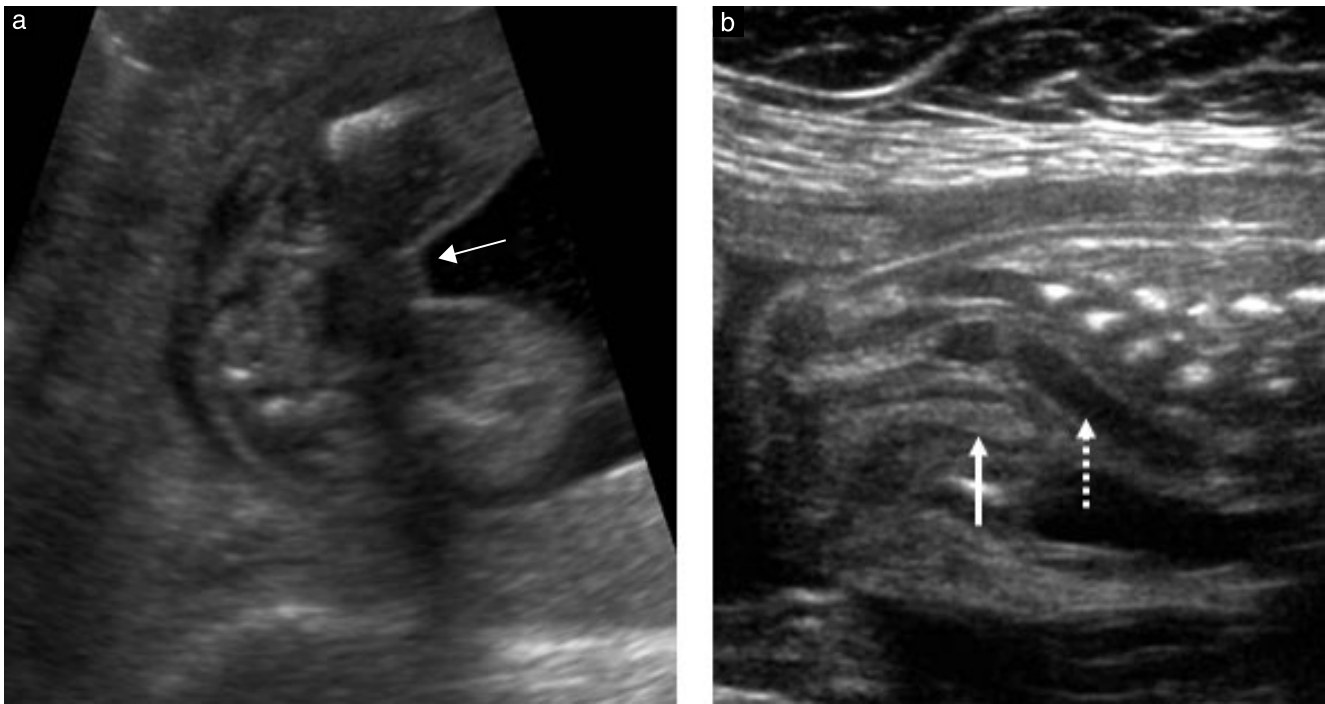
Transverse (a) and sagittal (b) ultrasound images showing normal female phenotypic genitalia: (a) at 19 weeks, showing external genitalia as four parallel lines of labia majora and labia minora (arrow); and (b) at 24 weeks, showing uterus and cervix with echogenic endometrium and cervical mucosa (arrow) surrounded by relatively hypoechoic myometrium, with rectum immediately posterior (dashed arrow).
